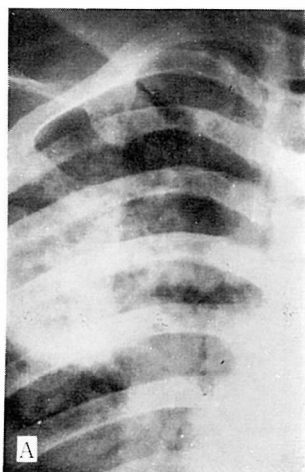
Case 3. T. F. A. Roentgenogram. B. Macroscopic findings.
